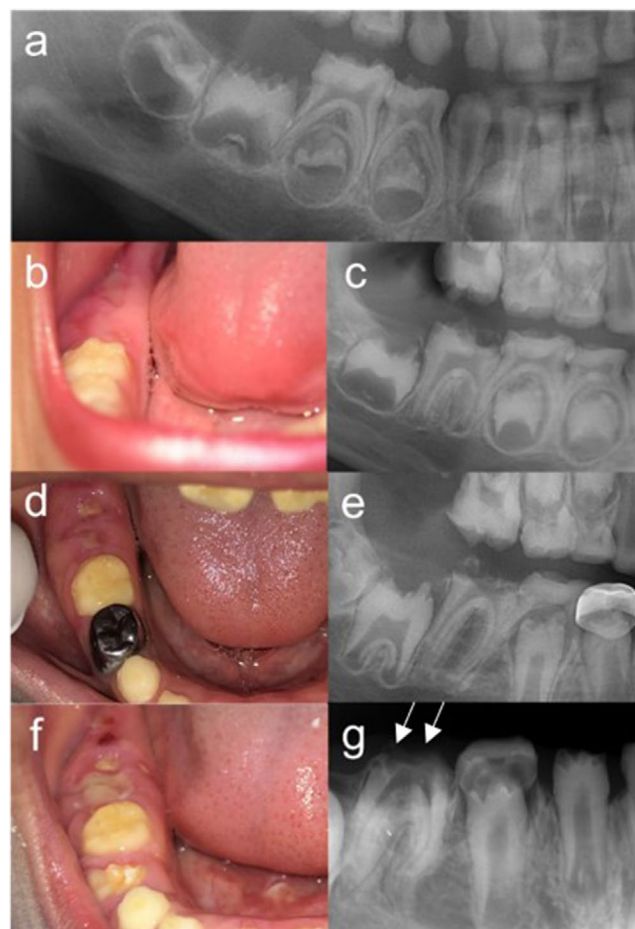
Long-term radiographic and clinical follow-up of external crown resorption on the first right lower molar (#46) of a patient with junctional epidermolysis bullosa and amelogenesis imperfecta. (a) Radiographic image of Patient 16 showing unerupted #46 at the age of 4 years and 7 months: complete crown formation. No contrast between enamel and dentin can be seen, compatible with generalised hypoplastic syndromic AI. (b) Same patient at the age of 7 years, 5 months: clinical image shows very early signs of eruption. (c) Radiographic image at 7 years, 10 months showing resorption of the unerupted mesial cusps. (d) Clinical picture at the age of 9 years: The molar does not erupt; the gingival tissue looks fibrous. (e) Radiographic image at the age of 9 years and 6 months showing severe crown resorption. (f) Clinical picture at the age of 9 years and 11 months, fibrotic gingival tissue in the area of tooth #46, that has not erupted. (g) Radiographic image at 10 years old, complete crown resorption of tooth #46. Only a thin layer of dentin covers the pulp chamber: 'perichamberal resorption-resistant sheet' (white arrows). Radicular dentin is unaffected.
